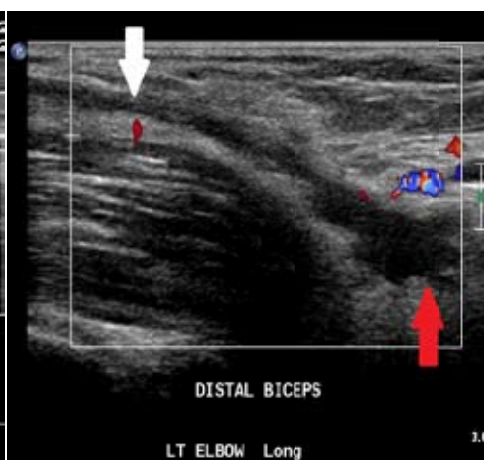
Ultrasound: The distal biceps tendon is ruptured. There is fluid and haematoma at the tendon defect (red arrow), and the tendon is retracted proximally (white arrow)
